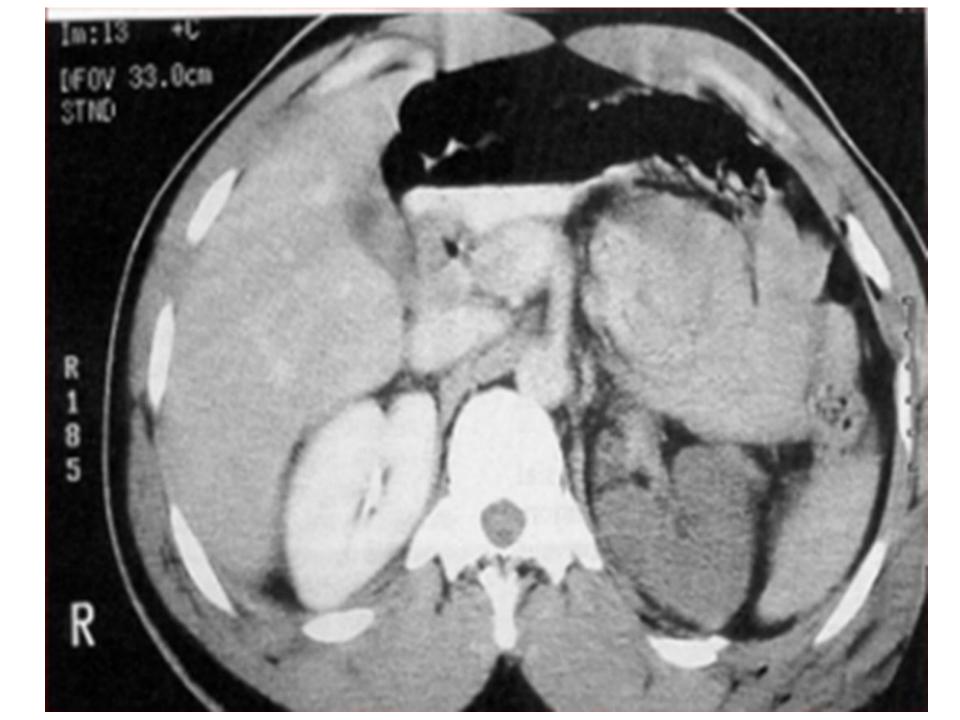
Computed tomography showing left renal fossa hematoma after blunt renal trauma, with bright jet of active extravasation of intravascular contrast indicating brisk active bleeding.
